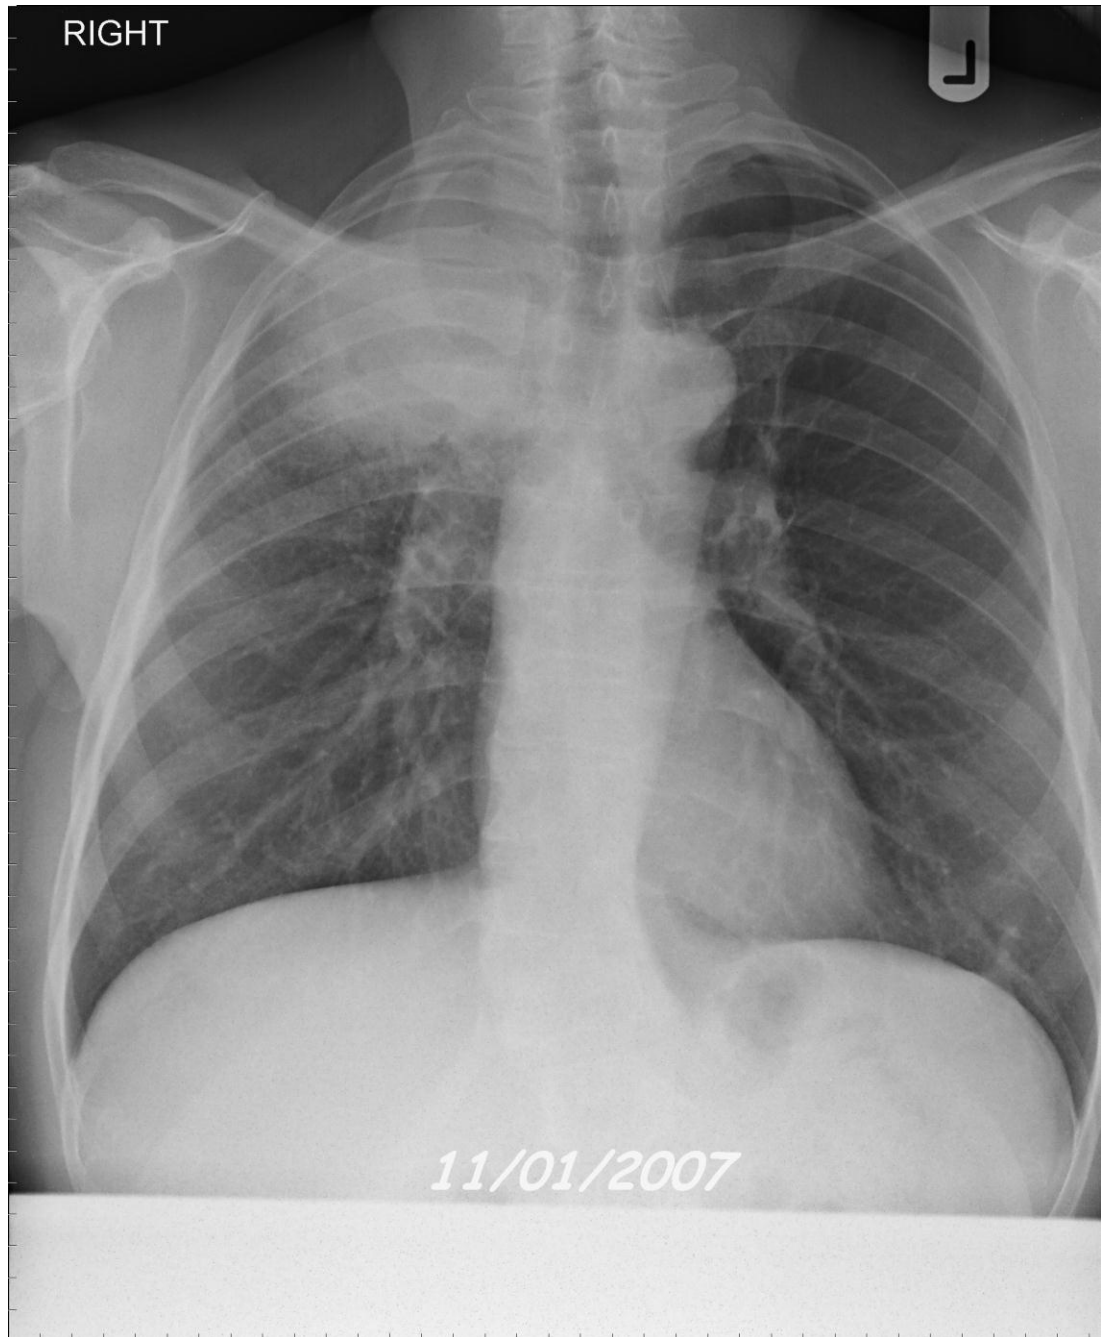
Plain chest radiograph showing a lesion in the apex of the right lung, later confirmed to be an adenocarcinoma.
